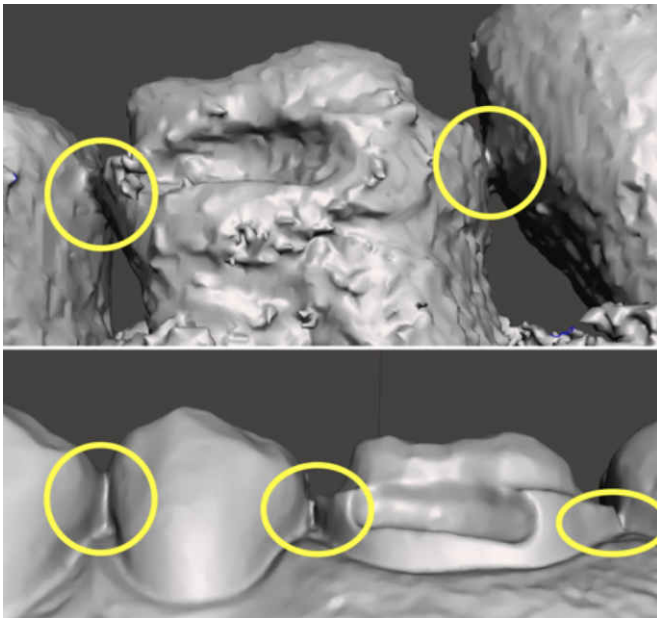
The buccal view of the prepared tooth stump can be seen in MeditLink. Unwanted contacts to the neighbouring teeth can be seen in the upper CBCT data and the lower scan data (yellow circles). In the comparison of the data, the gingiva is visible in the scan data, which is hidden in the X-ray.
